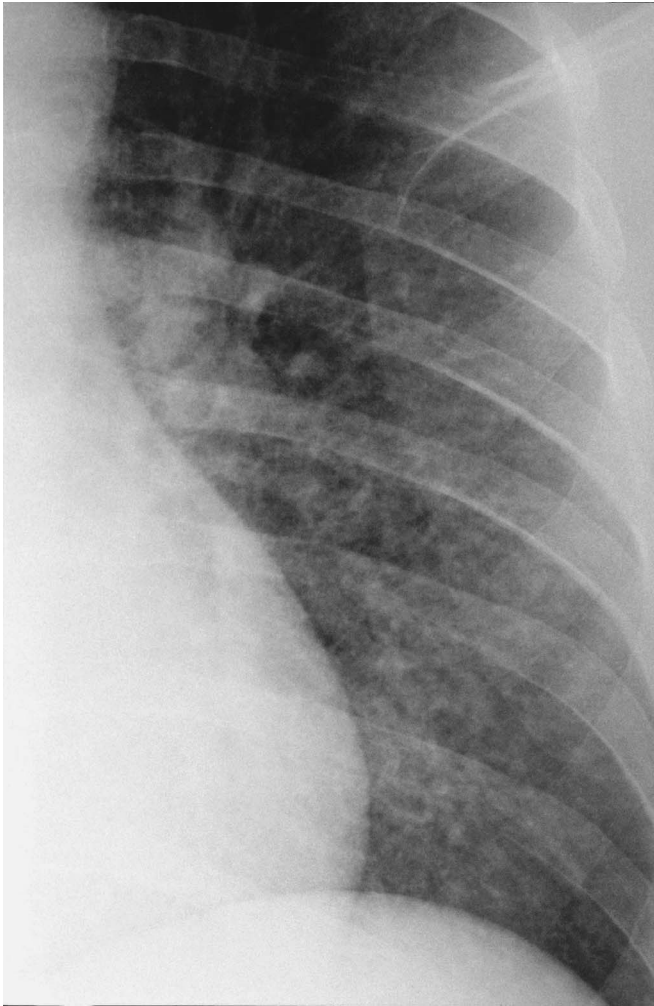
Radiograph of the patient's lung 6 weeks before appearance of 3 facial lesions.
